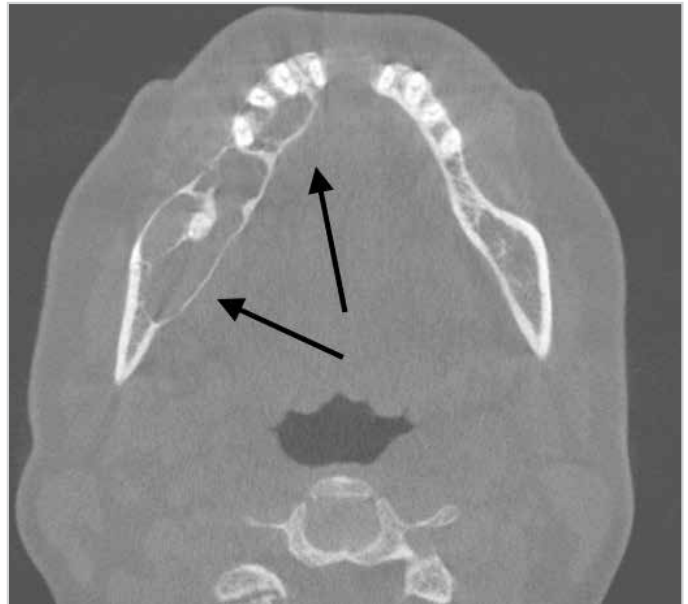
Axial paranasal computed tomography section showing the intraosseous tumor with intact cortical plates
